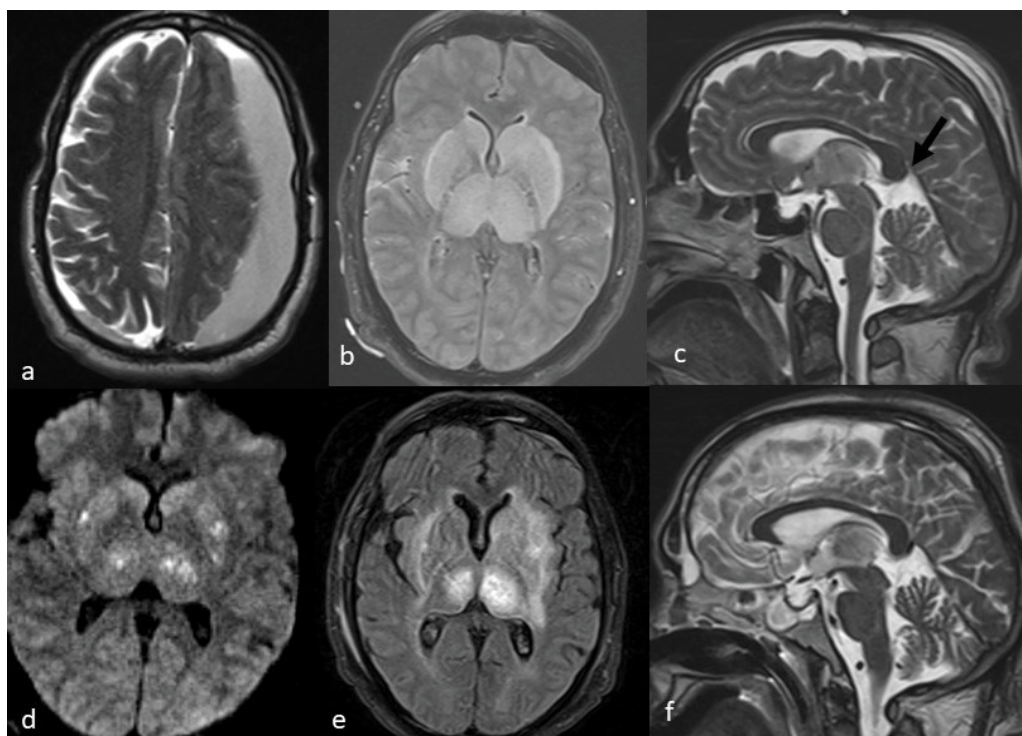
T2W MRI image (a) showing large left frontoparietal subdural hematoma. Postoperative FLAIR MRI image (b) show signal change and swelling in bilateral basal ganglia and thalamus, however only small focusses of diffusion restriction are seen (d), suggesting reversible swelling. Sagittal T2W image (c) shows vein of Galen compressed by splenium with increased angulation at vein and straight sinus junction Follow up MRI (e&f) after 9 days shows reversal of thalamic and ganglionic swelling with visualized Vein of Galen.
